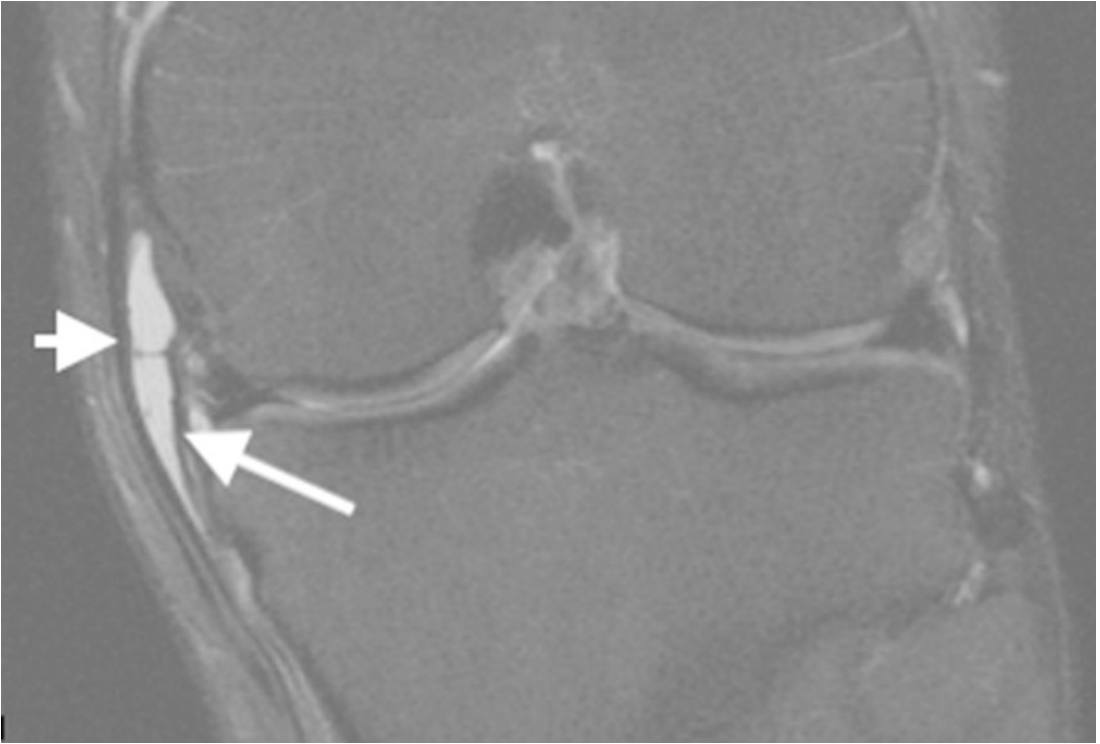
Peroneal nerve injury. Coronal proton density MR image. The common peroneal nerve is disrupted and recoiled (arrows) in this multiligamentous injury. The point at which the nerve is fixed at the fibular neck is shown (arrowhead)
